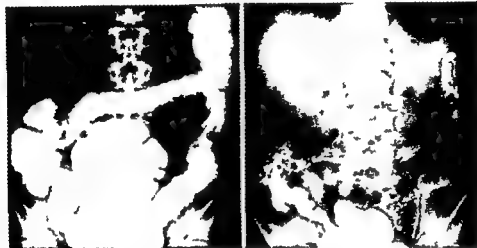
(Left) Chronic ulcerative proctocolitis. Roentgenogram showing contraction, marginal feathering and loss of normal haustrations. (Right) Roentgenogram after double contrast enema. Same case.
